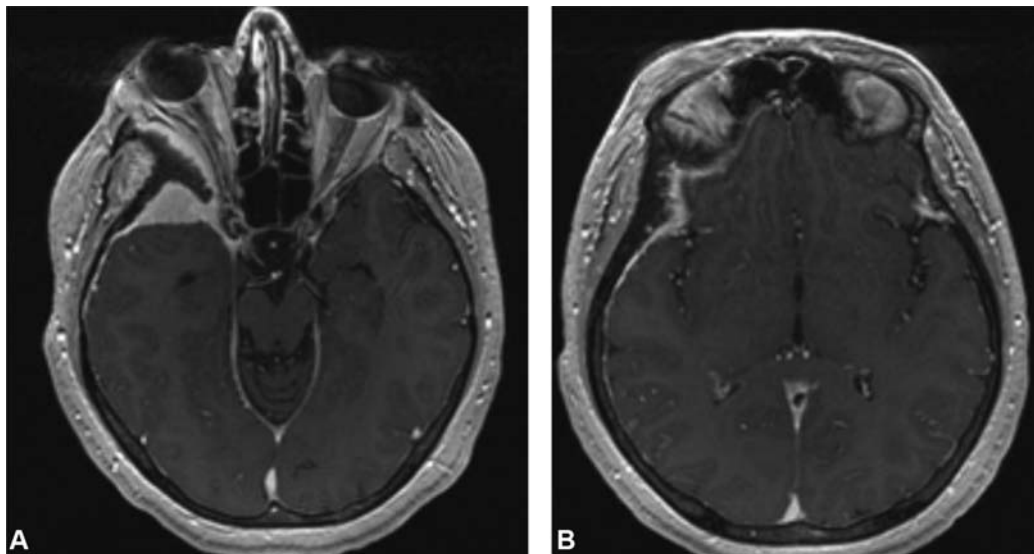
(A, B) Preoperative MRI showing dural thickening and frank tumor involvement of the anterior and lateral temporal dura, as well as a portion of the frontal and subfrontal dura in addition to lateral orbital periosteum. MRI, magnetic resonance imaging.
